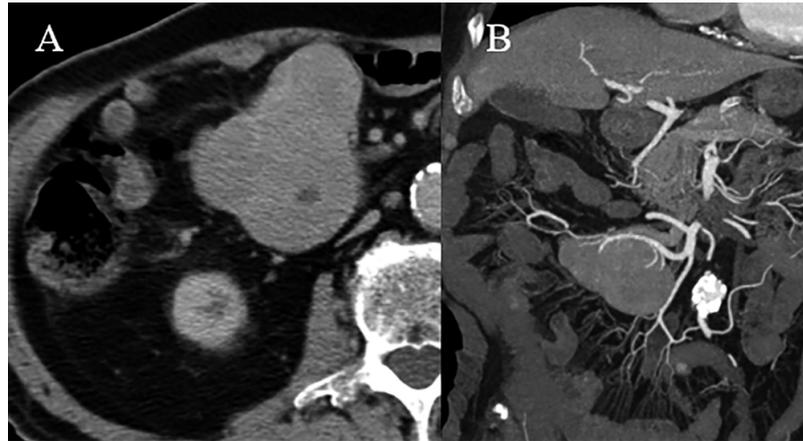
Abdominal computed tomography (CT) with contrast showing a lobular, heterogeneous mass measuring $80 \times 70 \times 60$ mm in diameter. The mass was slightly heterogeneously enhanced (A). Coronal CT image showing that the feeding artery of the mass was a branch of the superior mesenteric artery and ileocolic artery situated in the cranial surface of the mass.
